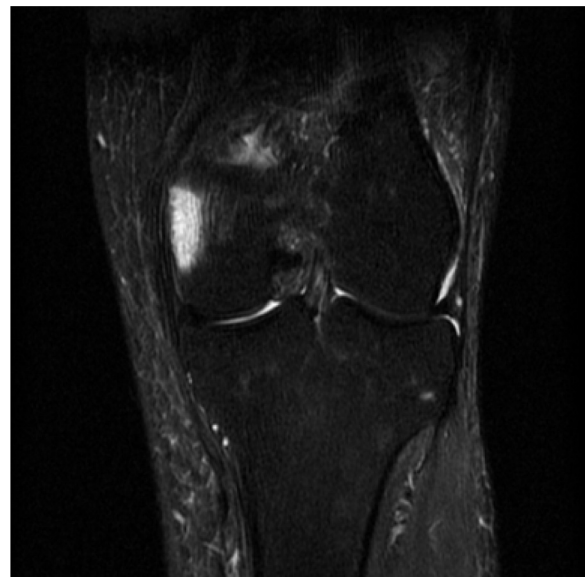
A follow-up MRI of the left knee after 12 months of treatment showing improvement of the osteomyelitis in the left femur.
